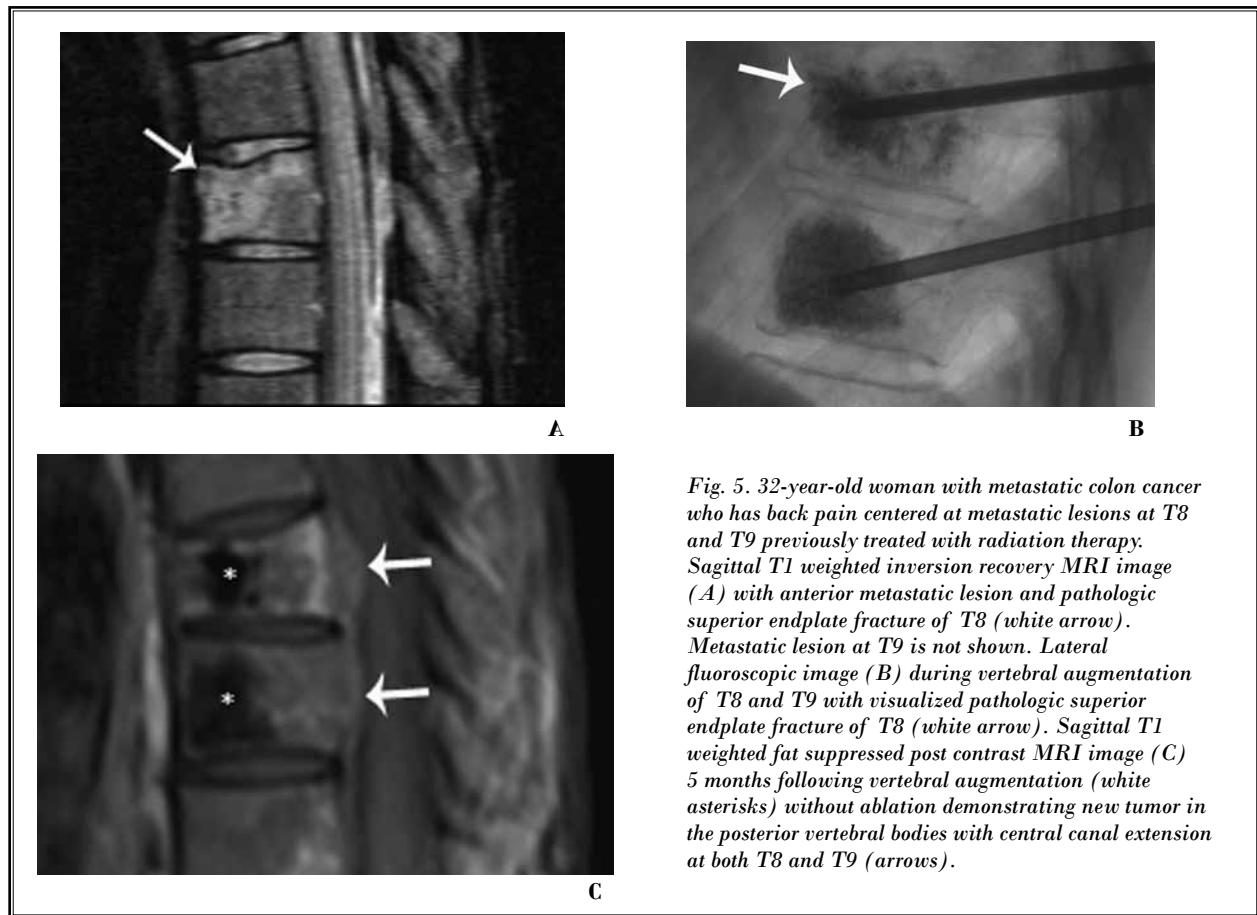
32-year-old woman with metastatic colon cancer who has back pain centered at metastatic lesions at T8 and T9 previously treated with radiation therapy. Sagittal T1 weighted inversion recovery MRI image (A) with anterior metastatic lesion and pathologic superior endplate fracture of T8 (white arrow). Metastatic lesion at T9 is not shown. Lateral fluoroscopic image (B) during vertebral augmentation of T8 and T9 with visualized pathologic superior endplate fracture of T8 (white arrow). Sagittal T1 weighted fat suppressed post contrast MRI image (C) 5 months following vertebral augmentation (white asterisks) without ablation demonstrating new tumor in the posterior vertebral bodies with central canal extension at both T8 and T9 (arrows).
